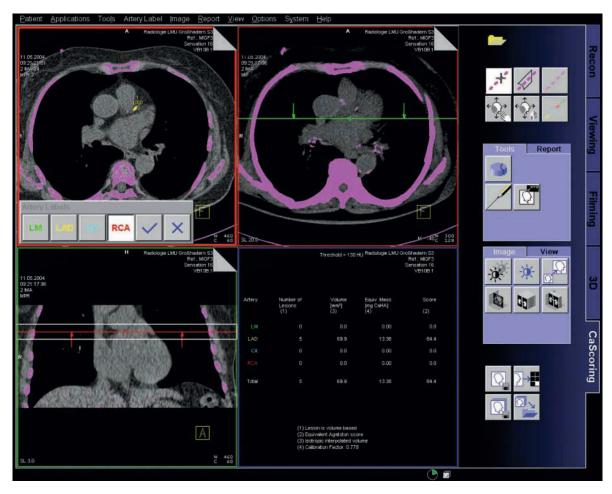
For quantification of coronary calcium, non-enhanced low radiation dose CT scans with 3 mm slice thickness are loaded into a post-processing workstation. After semi-automated identification of the calcified lesion in the coronary arteries, these workstations automatically provide quantitative data as the Agatston score, volume equivalent and mass
